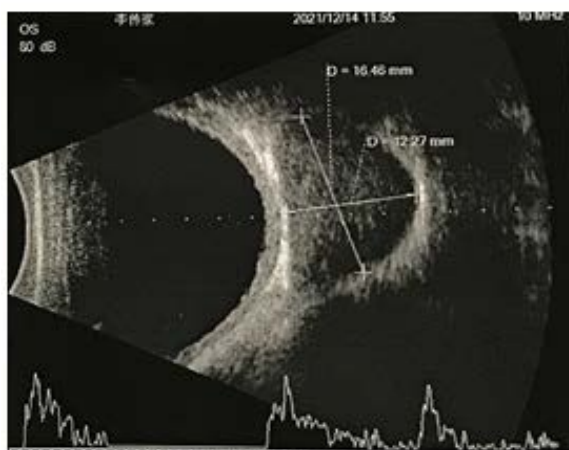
Ocular B-ultrasonography: An intraorbital occupying lesion in the left eye. A hypoechoic dark area with a size of about 17×13 mm was seen in the left superior medial orbit, with clear borders and relatively uniform internal echogenicity and signs of compression (-)
